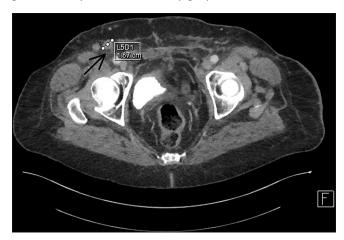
Patient's CT scan of pelvis. Pathological lymph nodes in the right groin region (arrow)
